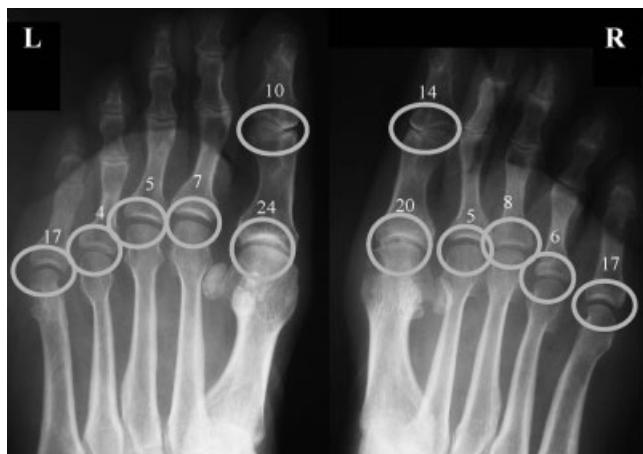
Localizations of foot joint abnormalities on oblique view. The circles represent the sites evaluated for radiographic abnormalities. Each number represents the number of patients with typical erosions at each site.
